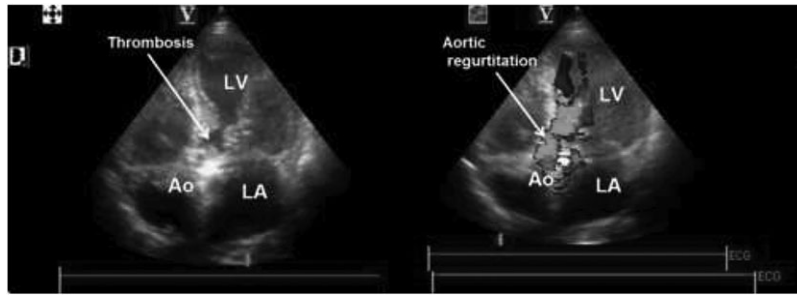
Transthoracic echocardiographic apical view of the thrombus formation on the prosthetic aortic valve and aortic regurgitation. Ao, aorta; LA, left atrium; LV, left ventricle.
